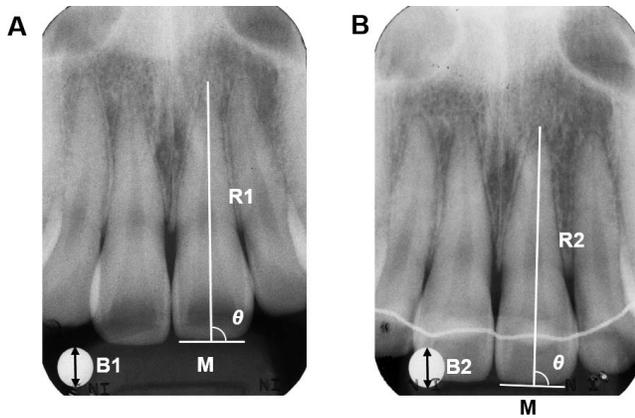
Measurement of apical root resorption using pretreatment periapical radiograph (A) and posttreatment periapical radiograph (B). R1 indicates pretreatment tooth length; R2, posttreatment tooth length; M, midpoint of the incisal edge; θ , intersection angle between the incisal edge and the long axis on the pretreatment radiograph; B1, pretreatment ball height; B2, posttreatment ball height.
